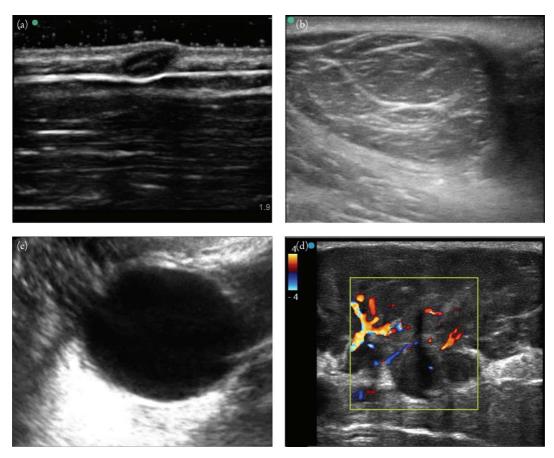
Variable appearance of cysts on ultrasound. Panel (a) shows an epidermoid cyst, which is typically small (<1cm), well-circumscribed, with a heterogeneous echotexture, and located in the skin layer. Panel (b) shows a lipoma, which is typically larger, isoechoic, and has internal hyperechoic swirls. Panel (c) shows a simple cyst, which is also round and well-circumscribed, with no internal echoes, and demonstrating posterior acoustic enhancement. Panel (d) shows a concerning complex cyst that is heterogeneous, vascular, and involves multiple soft-tissue layers.
